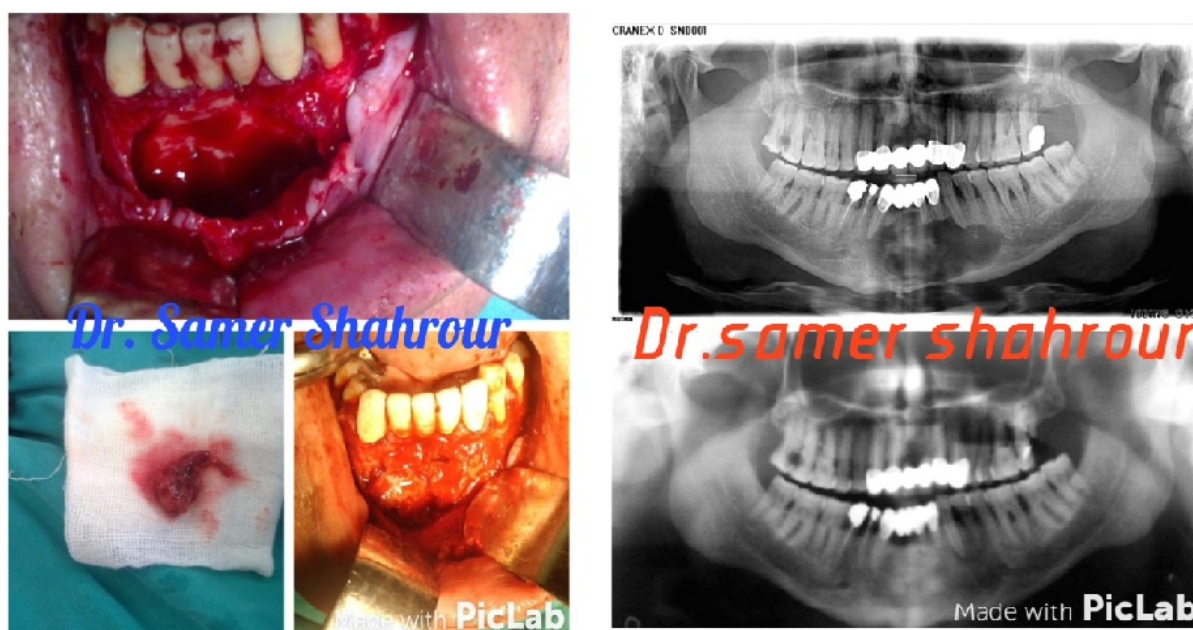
A healthy 52-year-old man was referred from his dentist for numbness in his lower lip, radiographic examination reveals a huge radiolucency lesion from 35 to 43. Surgical intervention was performed under general anesthesia via an intra-oral approach. The lesion was enucleated and an auto bone graft was harvested. Biopsy was sent, the report "Odontogenic cyst".
